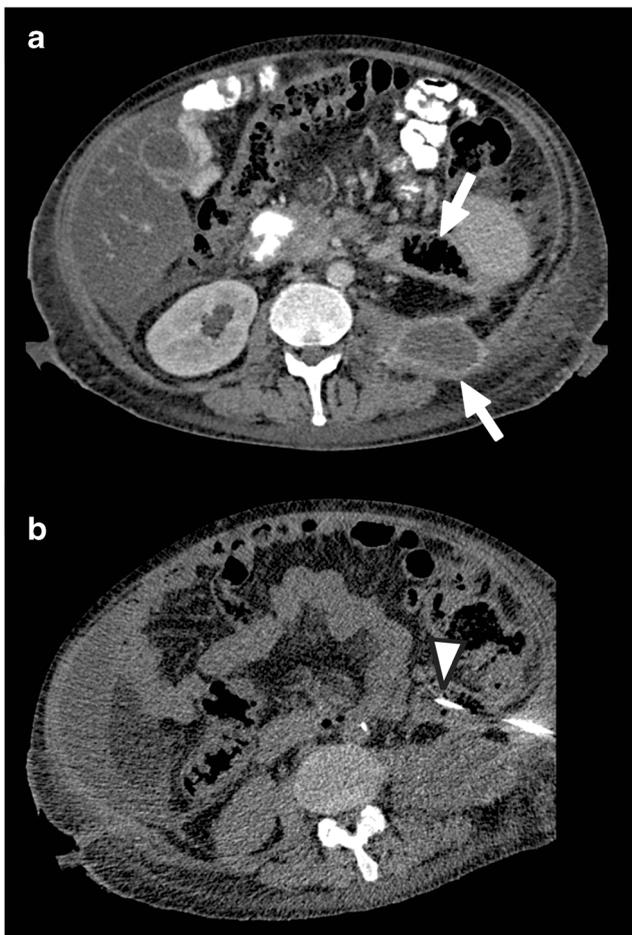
Aborted CT-guided intervention in a 49-year-old man with necrotizing pancreatitis who was referred for drainage of a peripancreatic collection. Diagnostic CT scan shows parts of the peripancreatic collection (filled with fluid and air) in the left retroperitoneal space that are communicating with each other (a, arrows). After planning CT, local anesthesia, and introduction of a guidewire in the peripancreatic collection (b, arrowhead), it was attempted to advance the drainage catheter. However, this was too painful for the patient, and the procedure had to be aborted. CT-guided drainage was successfully repeated under conscious sedation 10 days later
